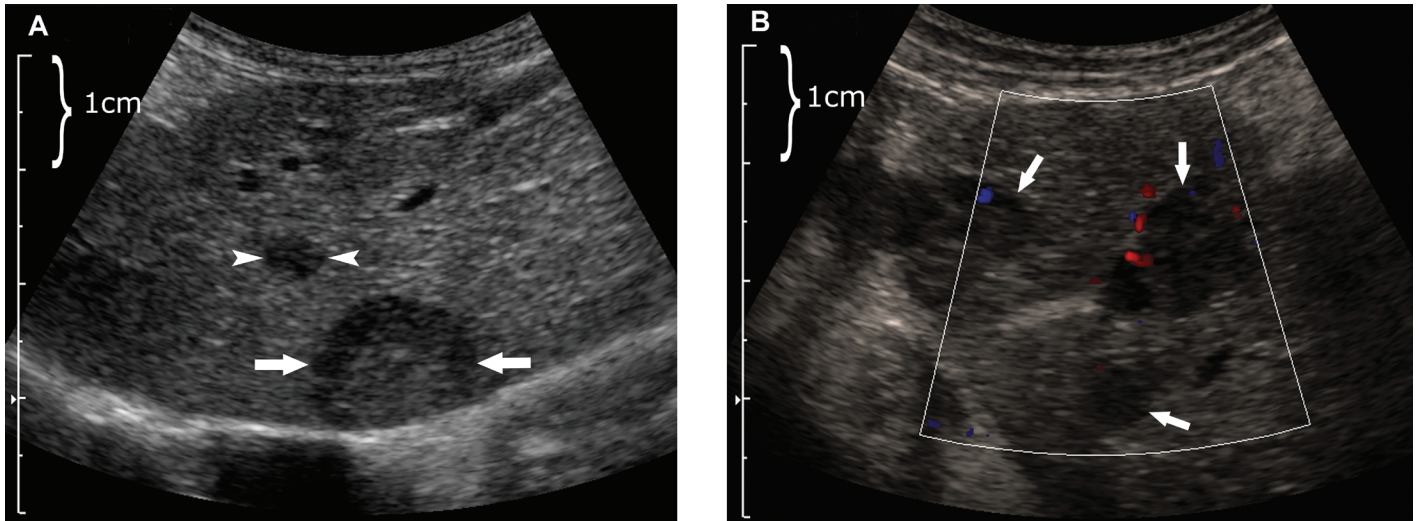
(A) Grayscale ultrasound imaging demonstrates a focal liver lesion (arrows) that measures approximately 16 mm in largest diameter and a smaller lesion (arrowheads) measuring approximately 6 mm. In another view, (B) color Doppler imaging demonstrates vascularity around and within multiple liver lesions (arrows). In this image, red indicates blood flow directed towards the ultrasound transducer whereas blue indicates blood flow directed away from the transducer. These lesions were pathologically proven to represent undifferentiated hepatic sarcomas.
